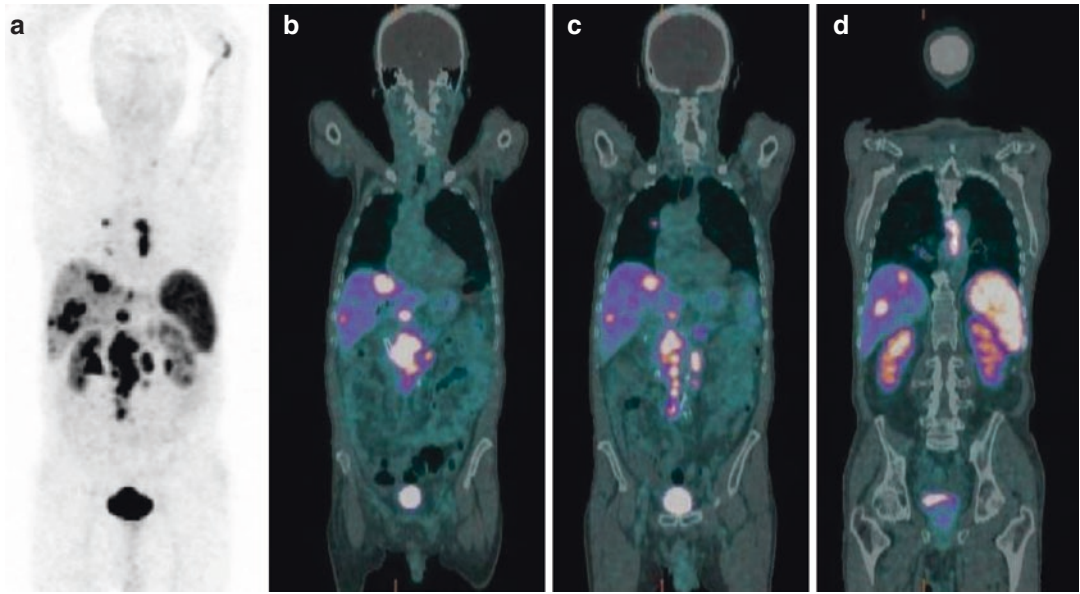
Patient submitted to surgery for ileal NET with subsequent disease progression. ^{68}Ga -DOTANOC PET/CT showed multiple areas of tracer uptake in the liver and in mediastinal and abdominal nodes as evident in the MIP (a) and in the fused PET/CT coronal slices (b–d)
